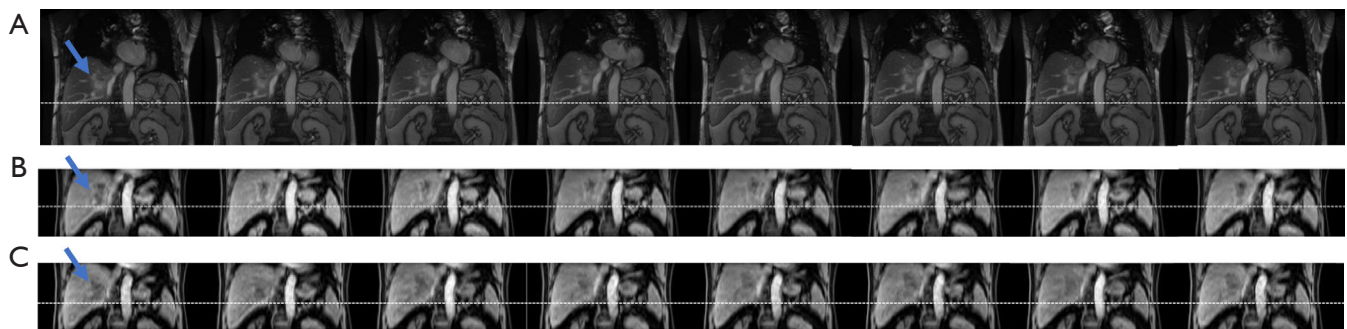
Coronal view of MRI images of an example patient. (A) 2D Cine MRI. (B) 4D-MRI_{CE}. (C) 4D-MRI_{NC}. The blue arrow indicates the position of the lesion, and the white dashed line is used to better visualize the motion. 2D, two-dimensional; 4D-MRI, four-dimensional magnetic resonance imaging; 4D-MRI_{CE}, contrast-enhanced 4D-MRI; 4D-MRI_{NC}, non-contrast 4D-MRI.
